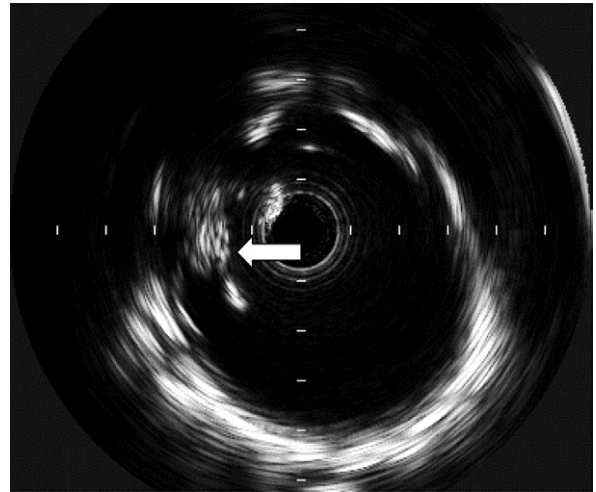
Intravascular ultrasound (IVUS) located the mobile thrombus attached to the medial wall of the descending thoracic aorta (arrow), which was consistent with the CT findings.
